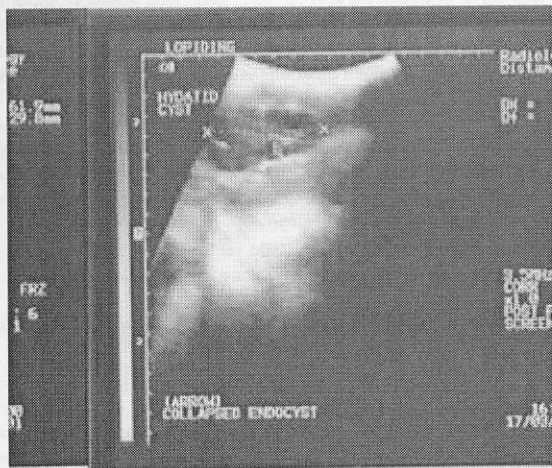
A sonogram of an *Echinococcus* cyst after puncture shows collapsed endocyst (arrow)
